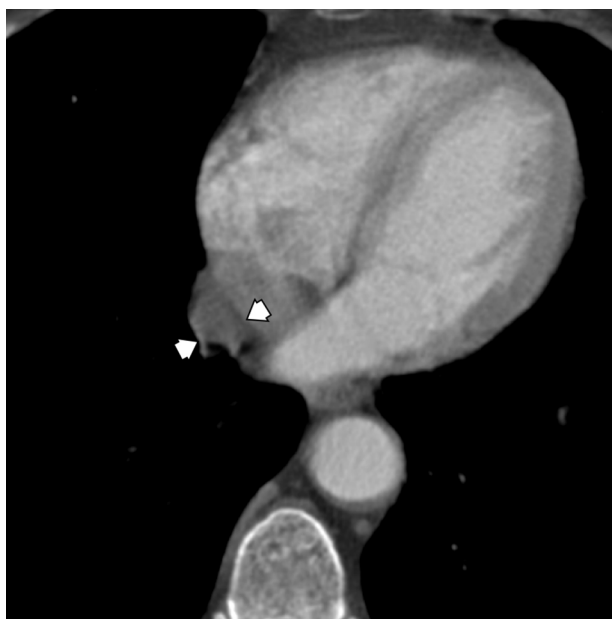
CT shows a cyst within the pulmonary ligament separated by fat plane from the pericardium.
